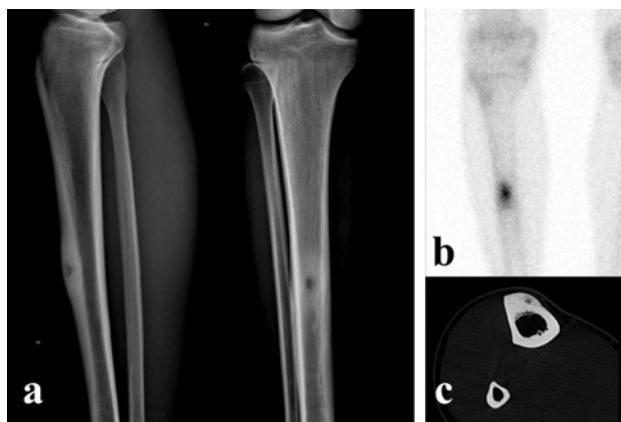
(a) Plain radiographs show intracortical osteoid osteoma of the tibia with reactive cortical sclerosis; (b) bone scan shows a classic "double density" sign; (c) Axial CT scan reveals a typical finding of small "nidus" surrounded by reactive bone.
